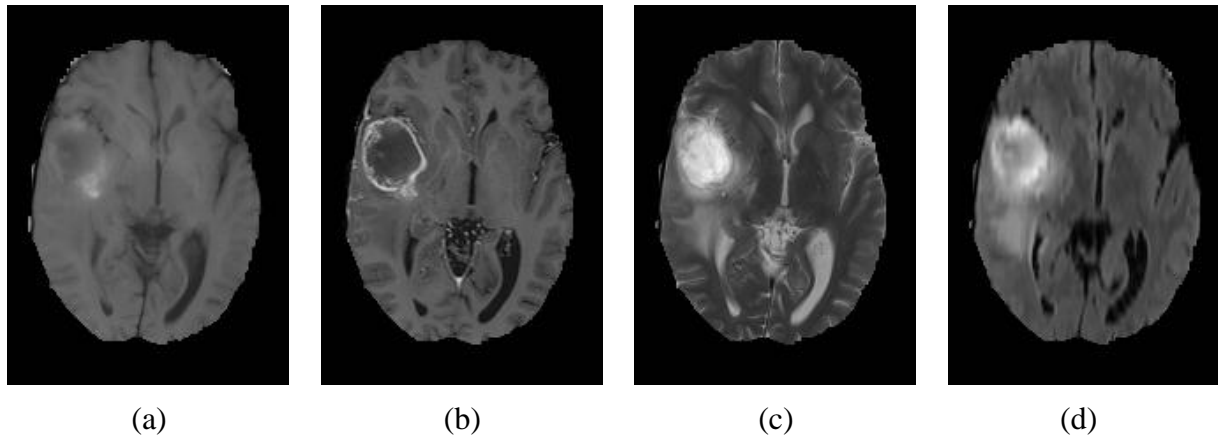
(a) T1-weighted (b) T1- weighted with contrast enhanced (T1c) (c) T2- weighted and (d) FLAIR MRI real image sequence of brain of single person with high grade tumour collected from BRATS 2012 dataset [4]
